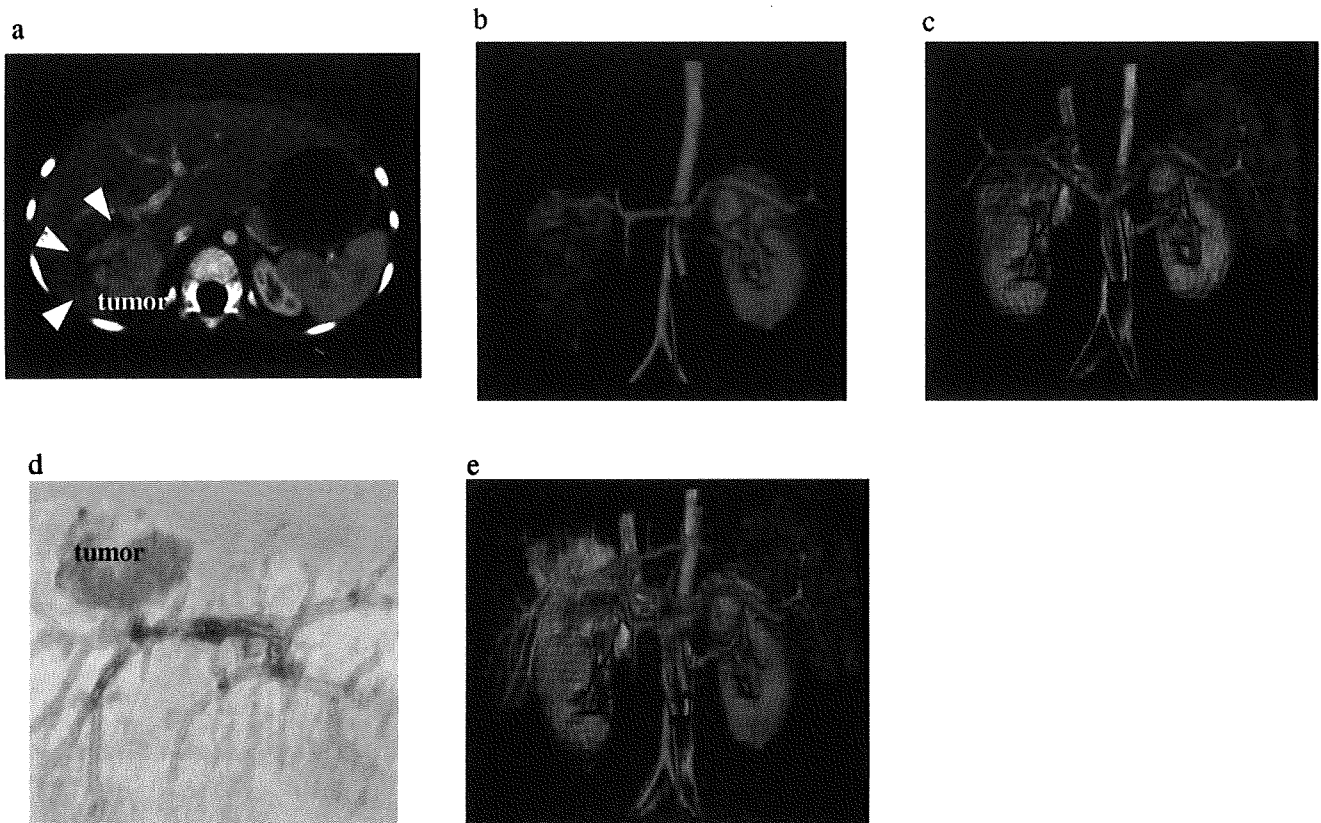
Each phase analysis (Case 5). (a) A 2-D image from a conventional CT. (b) A reconstructed image of the arterial phase. (c) A reconstructed image of the equilibrium phase. (d) A reconstructed image of the portal venous phase. (e) A reconstructed image of the combined multiphase images.
